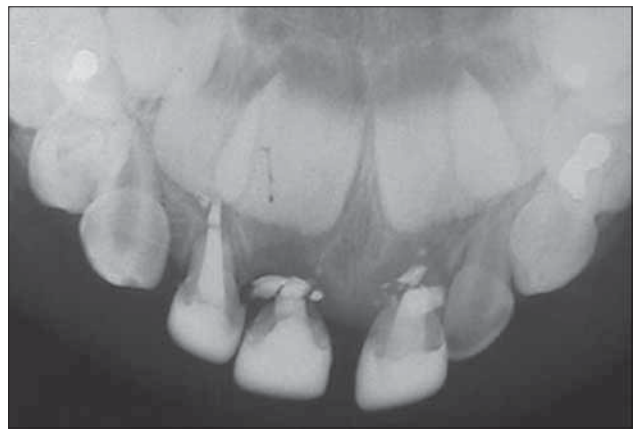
The same patient's radiograph at 10-month follow-up. The outcome was rated as a failure for the central incisors due to pathologic external root resorption.
